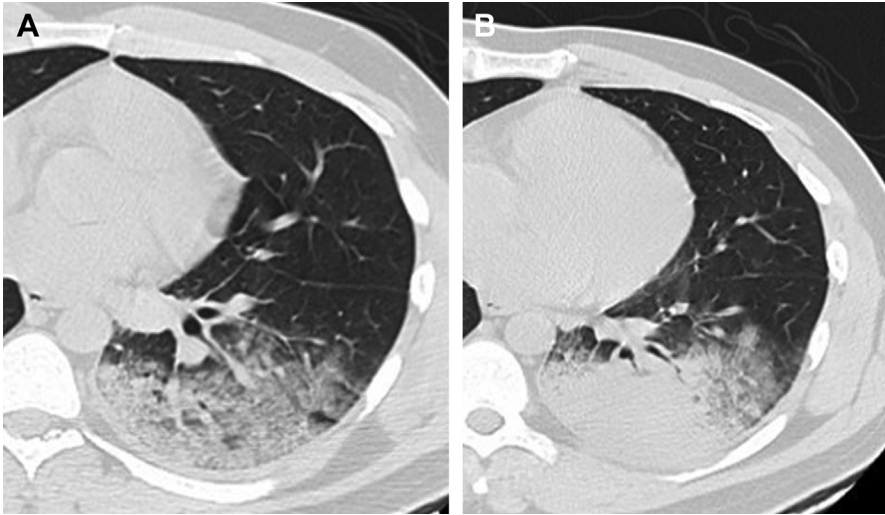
Adenovirus in an otherwise healthy man in his early 20s. (A, B) Axial chest CT images demonstrate focal left lower lobe mixed consolidation and ground-glass opacities.
